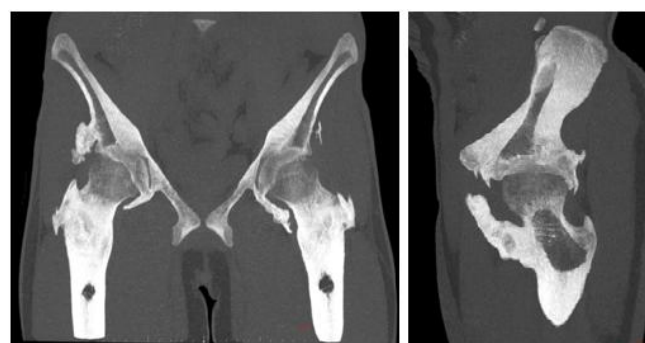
AP Radiograph of the pelvis (1a) and CT scanogram (1b) show extensive periarticular soft tissue ossification around the bilateral hip joints
